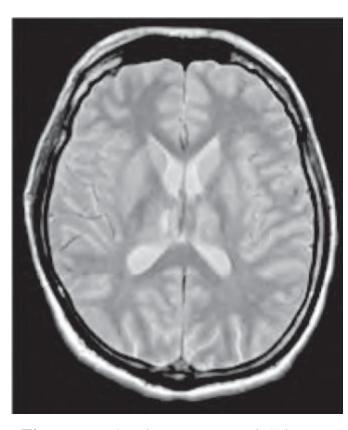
Proton density contrast weighting, TR=2400 ms, TE=30 ms. Signals with large proton density have higher signal intensity (CSF). This sequence produces a high peak SNR, even though the contrast differences are less than a T2-weighted image.
